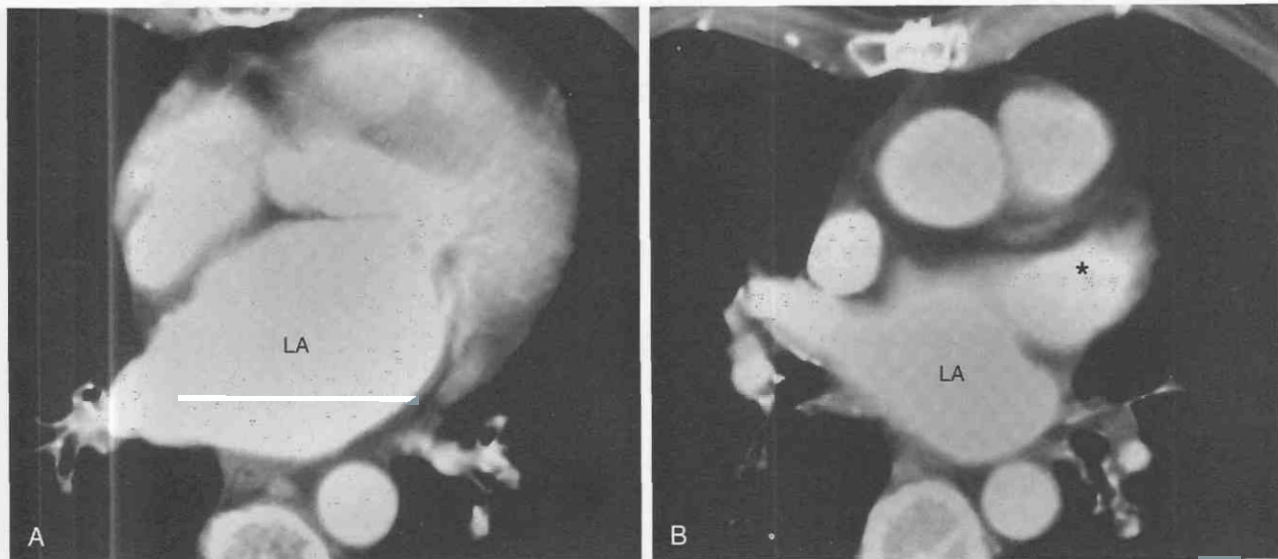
Mitral stenosis secondary to rheumatic heart disease. Axial CT with intravenous contrast medium shows (A) enlargement of the left atrium (LA) with (B) enlargement of the left atrial appendage (asterisk).
